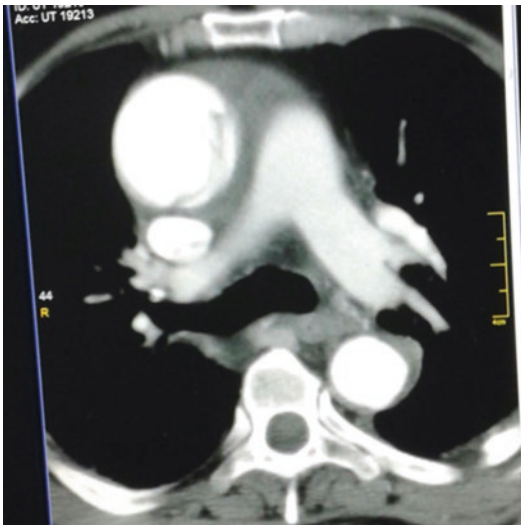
Computed tomographic angiography of the chest showing aortic dissection
